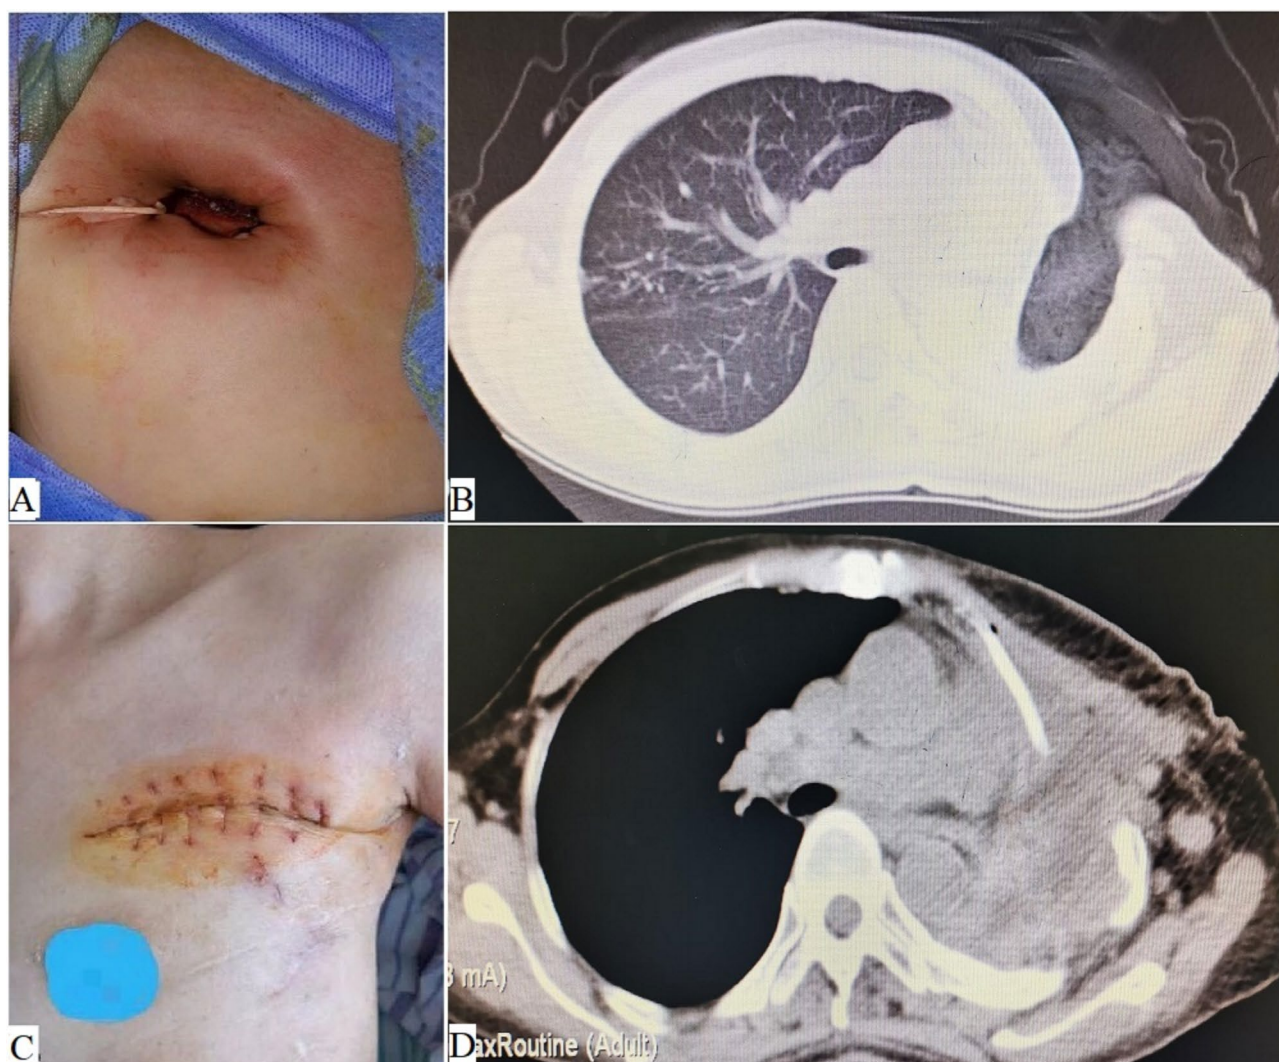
Clinical images of case 6. (A) The patient underwent OWT after first-stage surgery; (B) Chest CT showed a defect on the left chest wall after OWT; (C) The postoperative incision of case 6 healed well and the thoracic drainage tube had been pulled out; (D) After Clagett surgery, Re-examination of chest CT showed no recurrence of empyema
